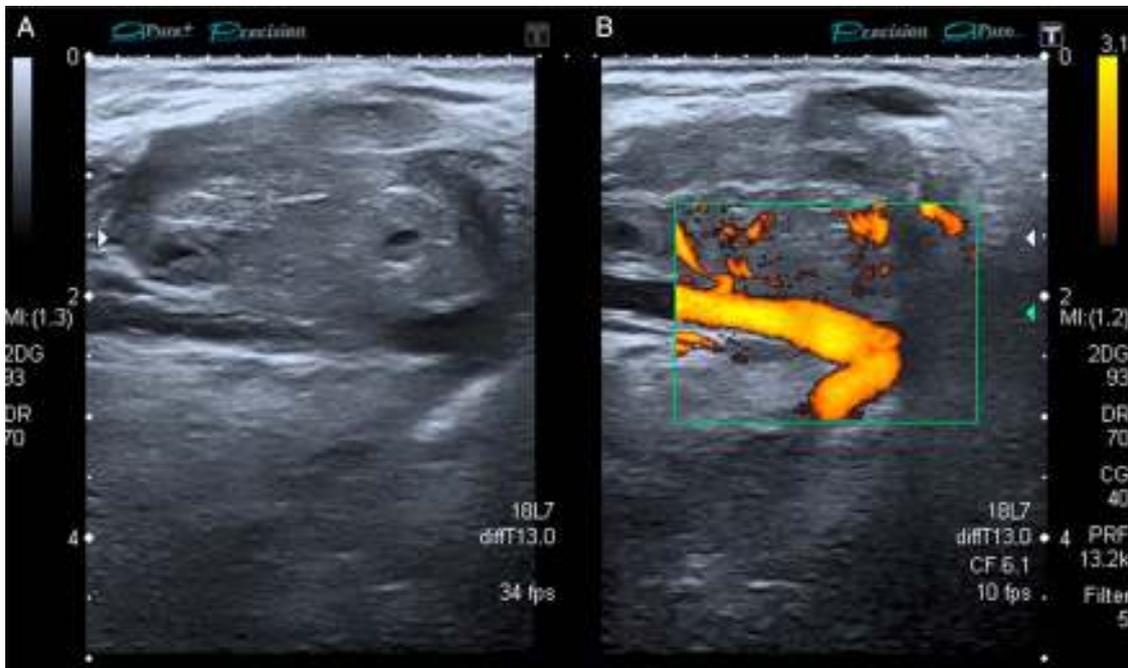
(A) Gray scale iso/hypoechoic image of a round, heterogeneous and moderately well-defined lesion. (B) Image with Doppler signal activated showing the vessel that feeds the metastatic lesion.
